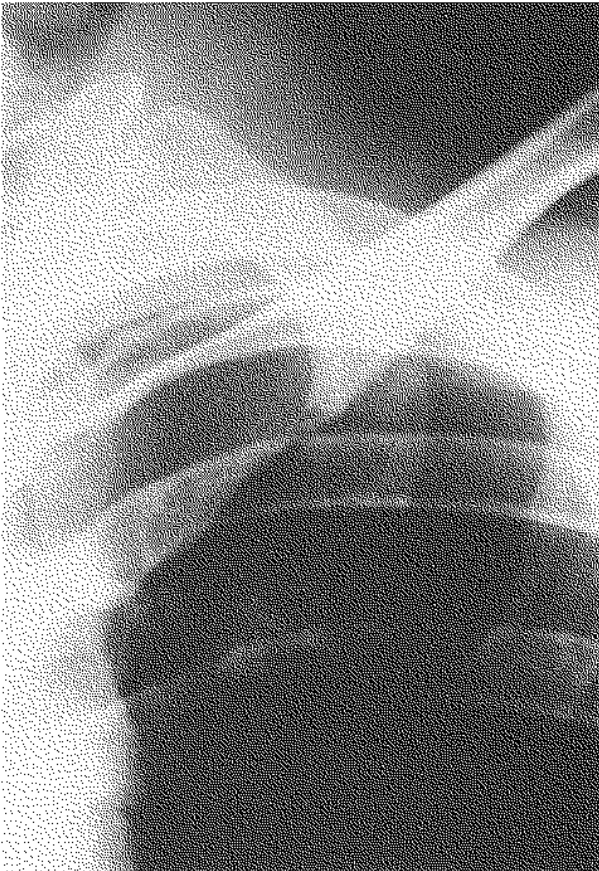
An AP radiograph of the upper chest at the first visit to our hospital demonstrated bilateral first rib fractures. The right first rib showed a transverse fracture line in the posterior segment, while the left first rib showed a transverse fracture line in the anterior segment.
